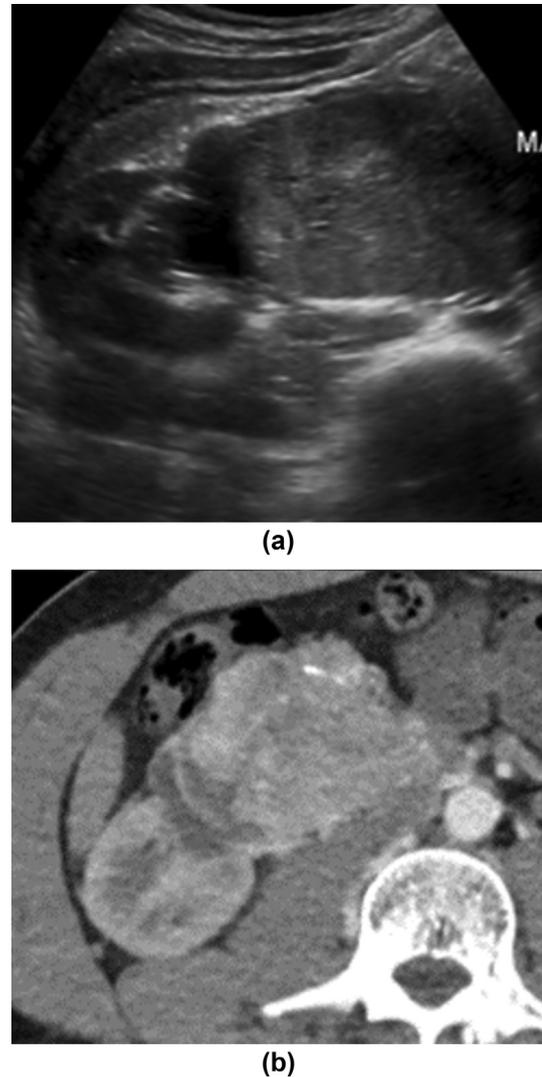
(a) Ultrasound image of a 26-year-old man with paraganglioma syndrome 4 showing a large heterogeneous right para-renal mass with areas of echogenicity likely indicating calcification. (b) Axial arterial phase CT image demonstrating the same para-aortic paraganglioma. Again, note the heterogeneous appearance and regions of calcification.
